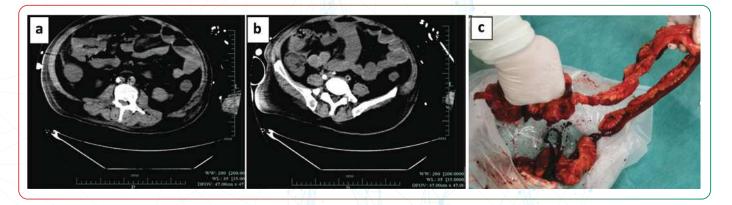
a and b) Preoperative abdominal computed tomography (CT). a) CT showing intestinal obstruction. b) CT showing an increased density in the intestinal wall. c) Postoperative intestinal perforation and necrosis.
